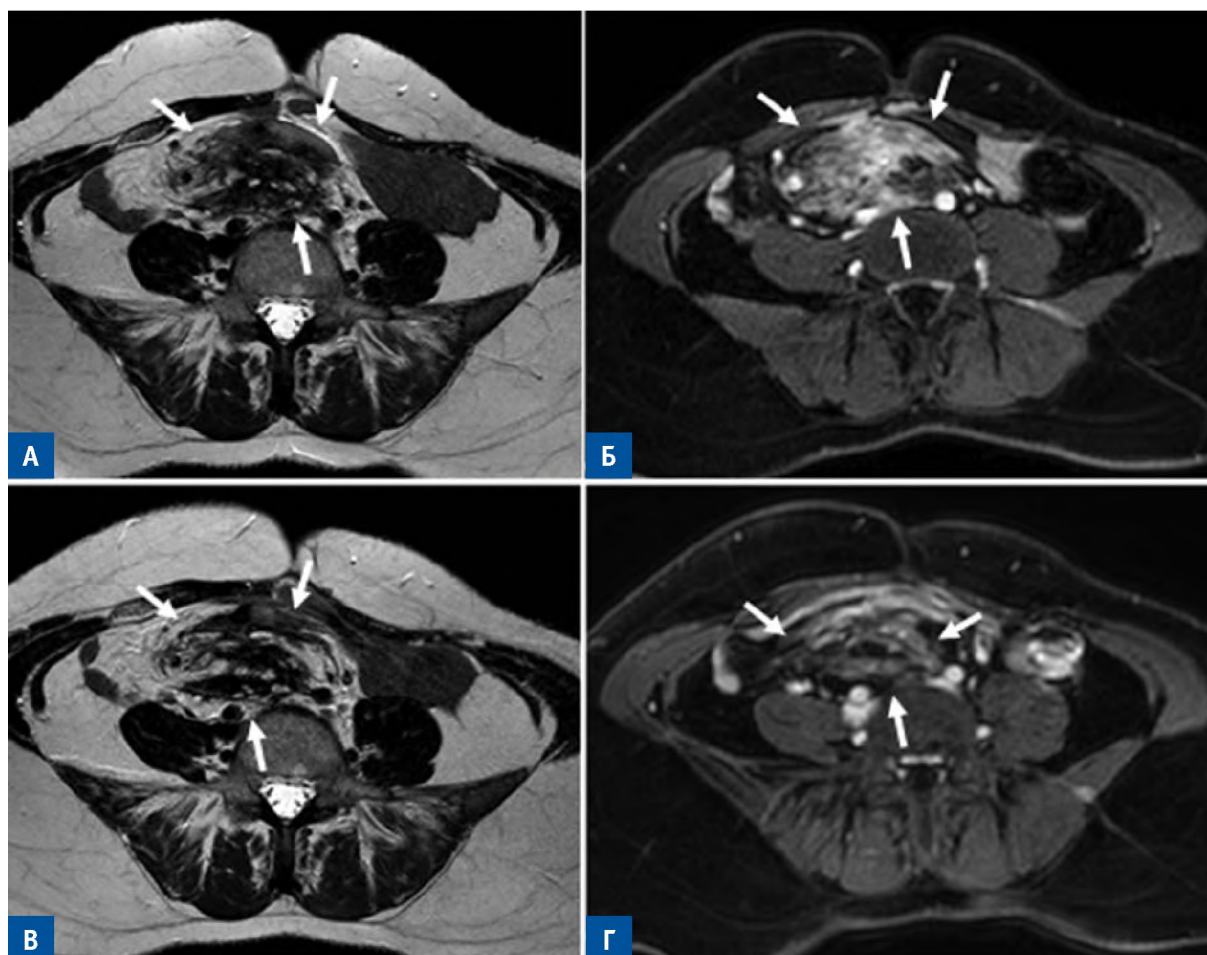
MRI with intravenous contrasting in patient Y, 39 years old. Axial projections. A, B — T2-WI; Б, Г — post-contrast T1-WI with adipose suppression. Infiltrative DF root of the small intestine mesentery; heterogeneous MR signal (A) with pronounced accumulation of contrast agent (Б) (arrows). In the study 12 months after chemotherapy, the area of the lesion did not change, there was a predominance of a hypointense MR signal (Б) with a slight accumulation of a contrast agent (Г) (arrows)
